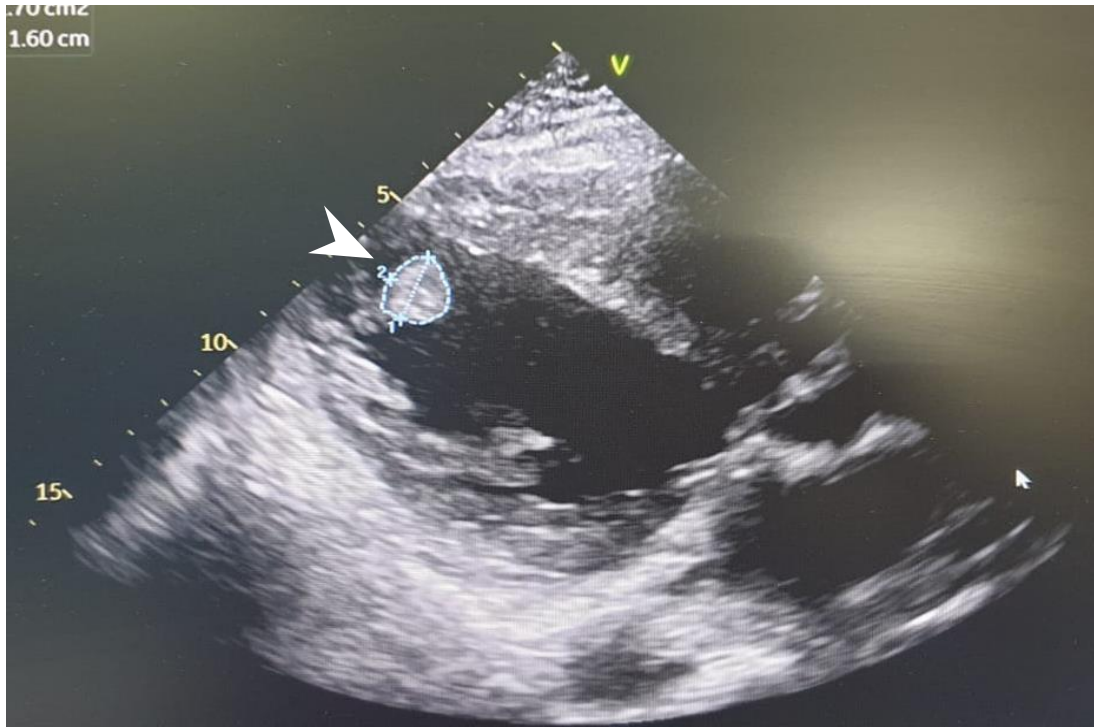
2D echocardiography shows dilated LA and LV with apical LV thrombus (arrowhead)
